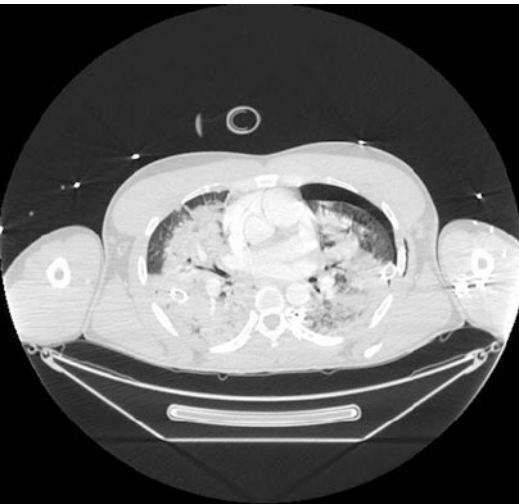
Computed tomography image of a soldier exposed to a significant explosion. The patient required immediate intubation and ventilation requiring a fractional inspired concentration of oxygen of 90 %. Shortly after intubation the patient was referred for ECMO though this was not subsequently required. The patient made a good recovery. Significant consolidation around the mediastinum and a left sided pneumothorax is seen (Courtesy of Lt Col Andy Johnson RAMC, Birmingham, UK)
